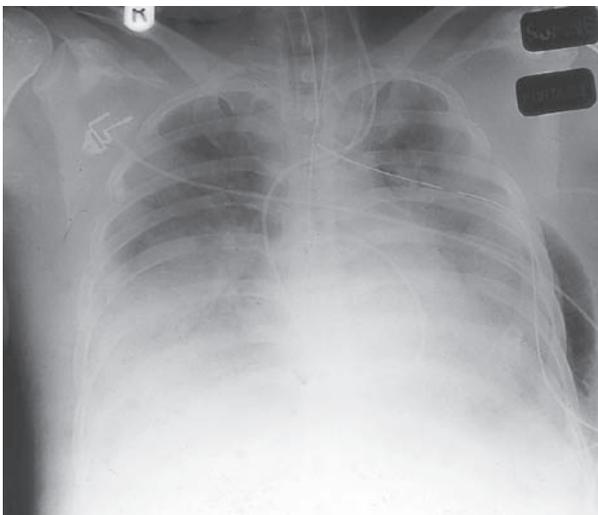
Chest radiograph of patient with ARDS*
